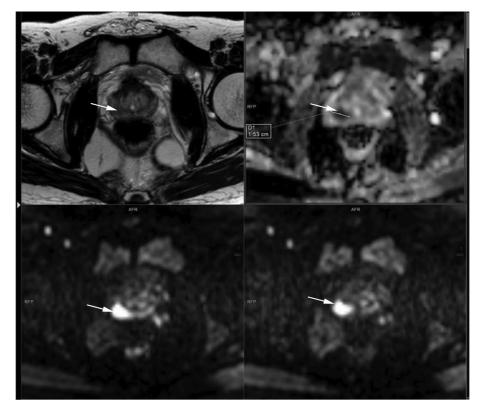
A focal well-defined T2 hypointense region in the right peripheral zone, showing marked diffusion restriction appearing hypointense on ADC and hyperintense on high b value DWI with early enhancement on DCEI measuring more than 1.5 cm. Features are consistent with a PIRADS 5 lesion. The lesion shows >1 cm smooth contact with the adjacent capsule, a sign of EPE. Note the difference between PIRAD 4 (< 1.5 cm) and PIRAD 5 (>1.5 cm) lesions are only size. Moreover, any capsular or NVB invading lesions are PIRAD 5 irrespective of size.
